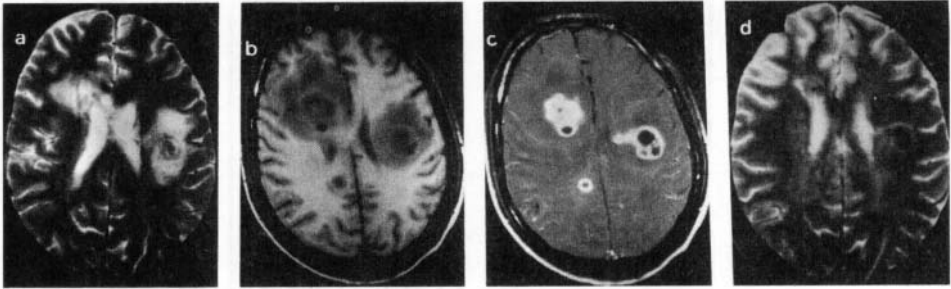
Chronic abscess. T2-weighted image (a) shows multiple bilateral lesions with perifocal edema. Lesion on the left side shows a subtle hypointense rim. Pre- (b) and postcontrast (c) T1-weighted images show multiple rounded confluent hypointense lesions bilaterally with ring enhancement. Blood culture showed *Staphylococcus aureus*. Follow-up after 6 months of antibiotics reveals that most of the lesions have disappeared. The lesion in the left periventricular region shows hypointensity on T2-weighted image (d).
